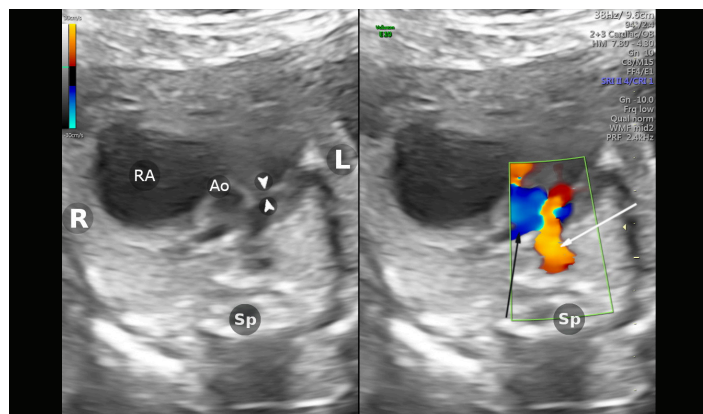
RVOT view using normal colour Doppler at 21 weeks, showing a severely dilated right atrium (RA). The pulmonary valve is shown between the white arrowheads. There is reversal of flow in the arterial duct (white arrow). The right pulmonary artery also demonstrated (black arrow).
